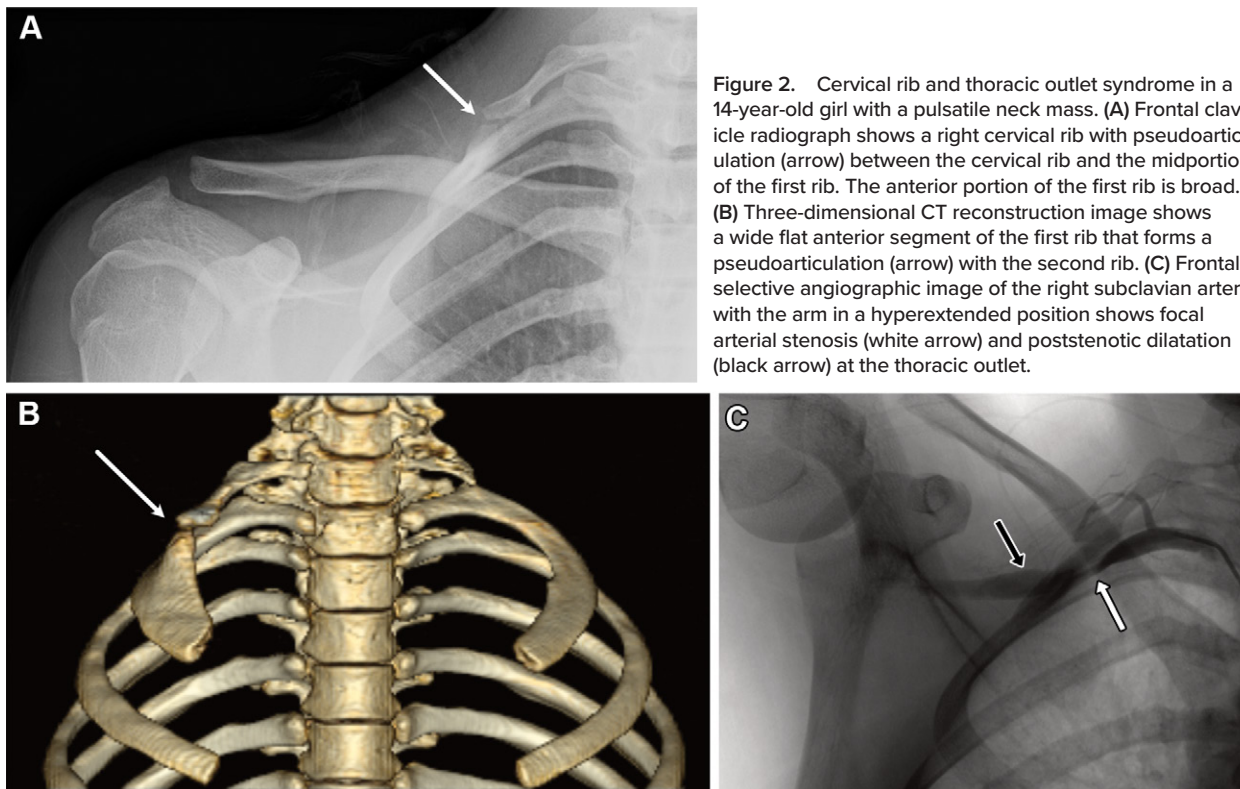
Cervical rib and thoracic outlet syndrome in a 14-year-old girl with a pulsatile neck mass. (A) Frontal clavicle radiograph shows a right cervical rib with pseudoarticulation (arrow) between the cervical rib and the midportion of the first rib. The anterior portion of the first rib is broad. (B) Three-dimensional CT reconstruction image shows a wide flat anterior segment of the first rib that forms a pseudoarticulation (arrow) with the second rib. (C) Frontal selective angiographic image of the right subclavian artery with the arm in a hyperextended position shows focal arterial stenosis (white arrow) and poststenotic dilatation (black arrow) at the thoracic outlet.
